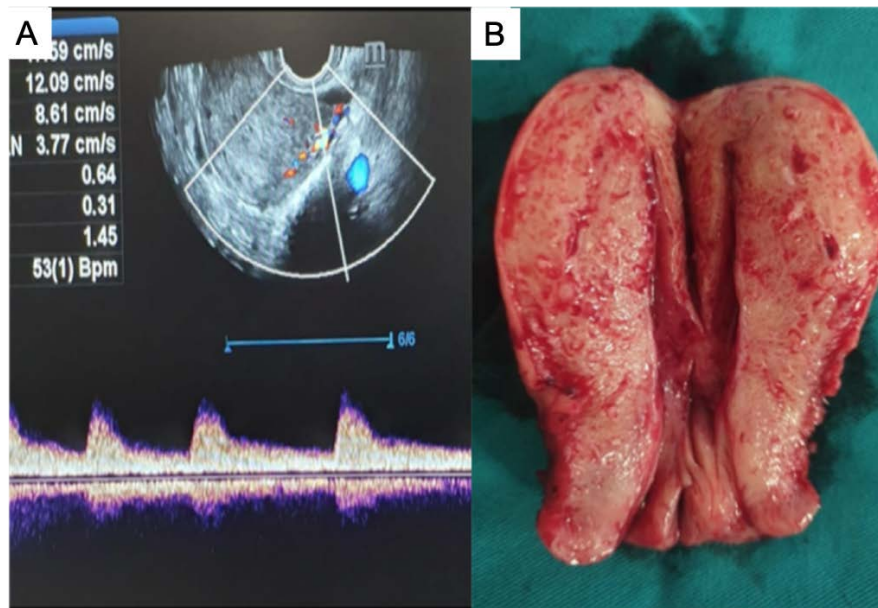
A) Gynecologic ultrasonographic image of the first patient reveals a suspicious mass in the right uterine cornu, intimately beside the uterine cavity; B) Uterus after the hysterectomy.
